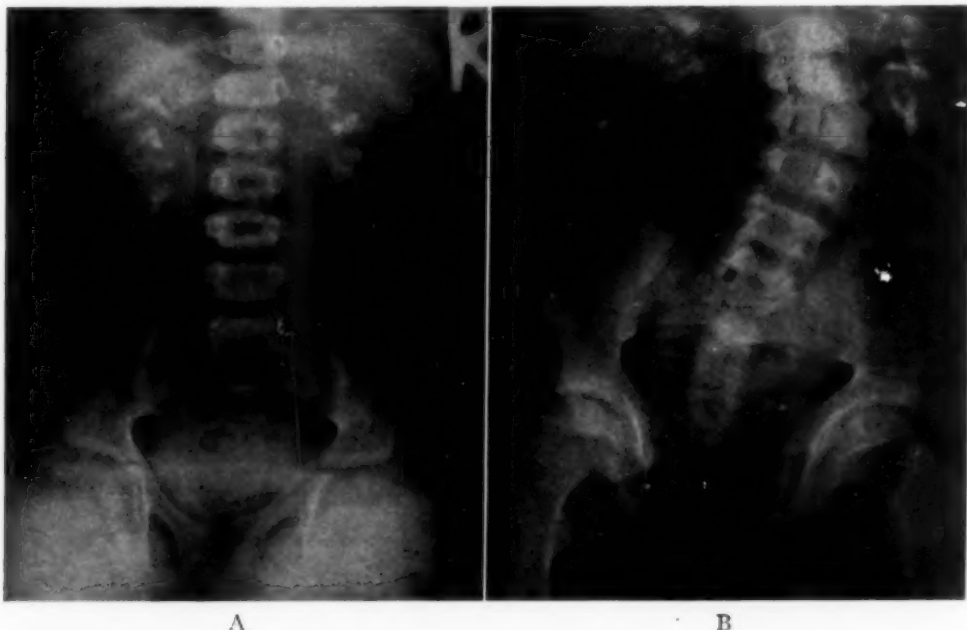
In A is shown a roentgenographic plate of the spine taken of the patient presented in case 1, at the age of nine years. In B is shown the progressive deformity that took place during the following six years, in spite of attempts to prevent it with orthopedic measures. The calcification of the renal pyramids is evident in both plates. (These roentgenograms and those of figure 2 are reproduced through the courtesy of Dr. J. P. Rousseau, Roentgenologist-in-Chief, The North Carolina Baptist Hospital.)
